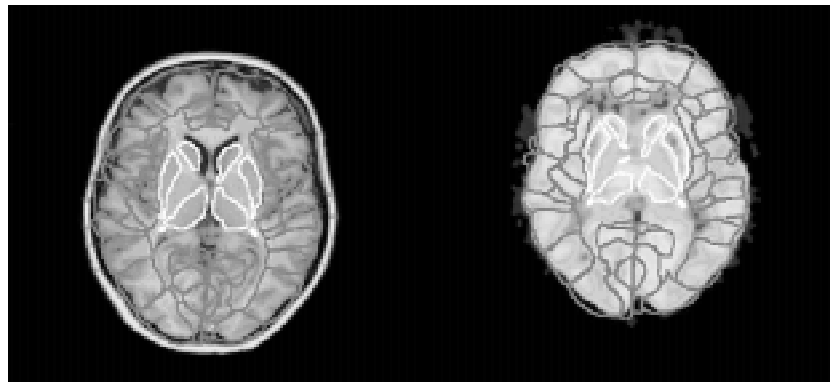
Computed brain atlas template fit to an MRI (left) and to a SPECT study before spatial standardization. All cortical brodmann areas and central structures are defined by the atlas volumes of interest.
